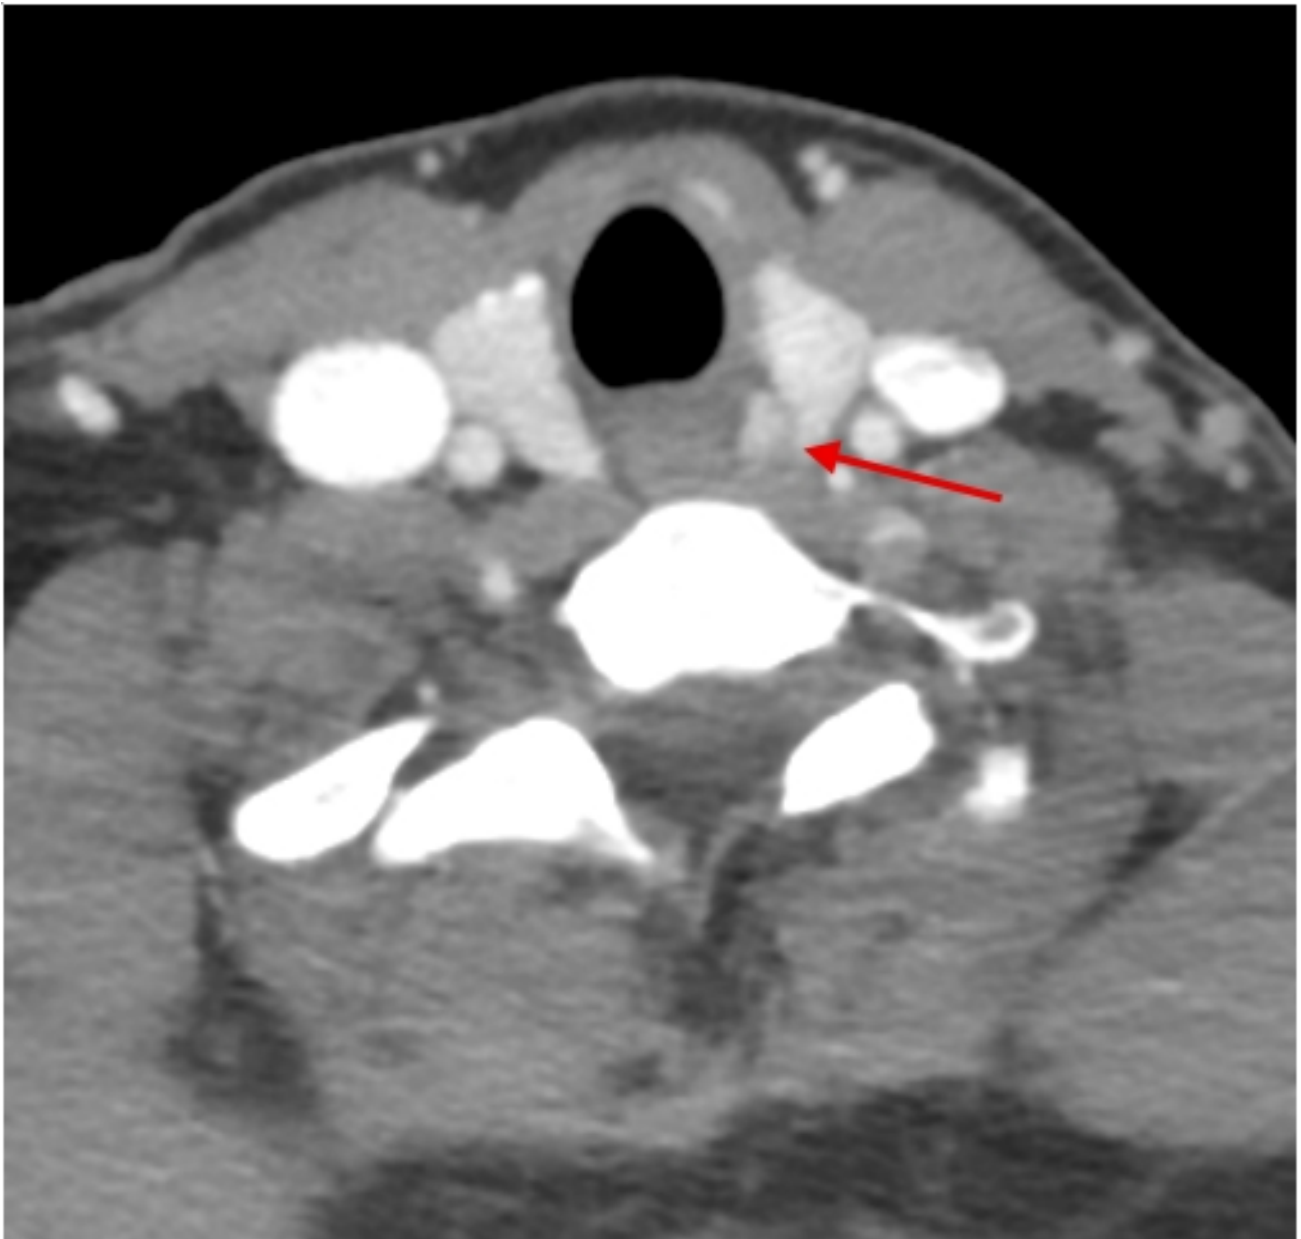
4D-CT at 30 sec post contrast showing a left superior parathyroid adenoma marked by a red arrow. 4D-CT, 4D-computed tomography.
